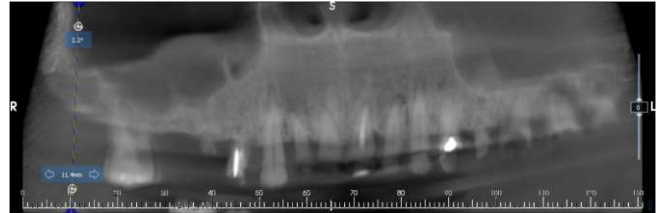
Panoramic radiograph (OPG) showing sufficient bone in the premaxilla and insufficient bone beneath the maxillary sinus.
